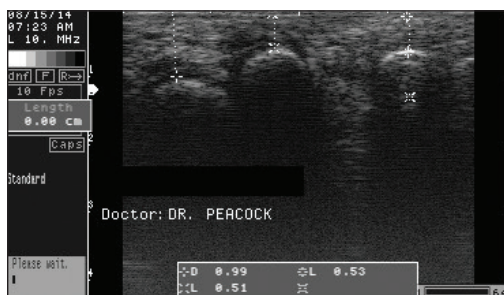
Ultrasound view pre-operatively.
